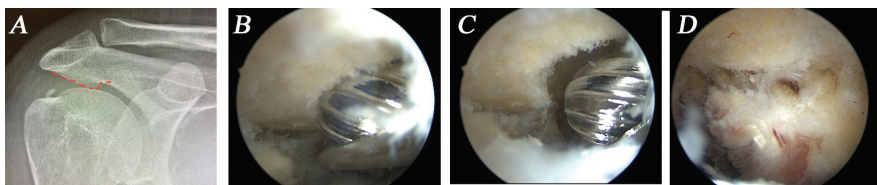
A. AP view of the X-Ray showing the spur of the acromion. B. Spur of the acromion in the arthroscopic view. Acromioplasty starts with arthroscopic burr C. Arthroscopic image shows how the burr resects the lateral portion of the acromion D. The arthroscopic image after the subacromial decompression (SAD). The subacromial space has become wider after SAD
